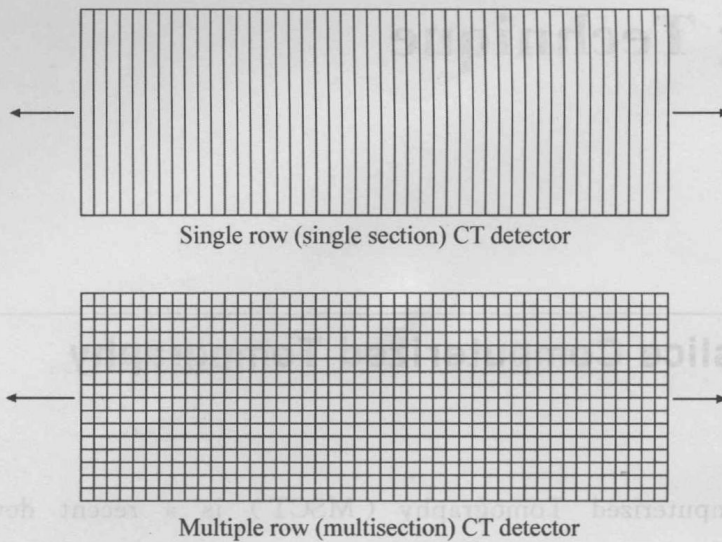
MSCT Single section CT detector (top). Each detector element is about 1mm wide by 20 mm high, MSCT detector (bottom). The single section CT detector is replaced by multiple elements
